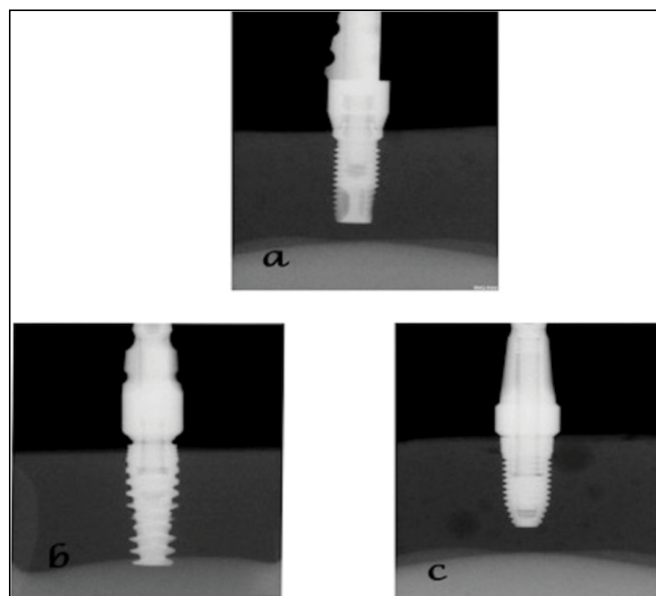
Radiographic images in 0° tube angulation without gap: a) system B, b) system NA, c) system NR.
